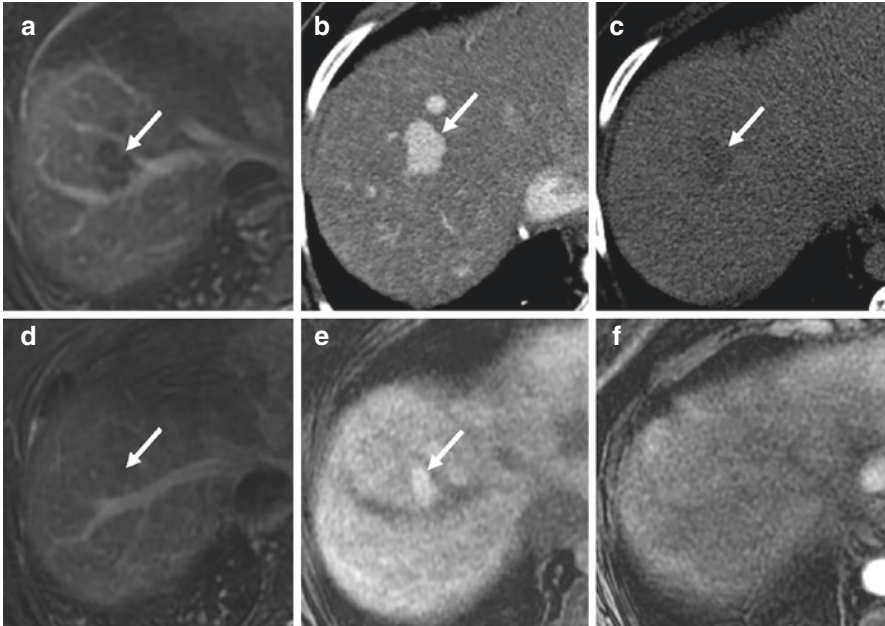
Patient with multiple T2 hypointense masses, one of which is shown (arrow, a). Nodules in this patient showed arterial phase hyperintensity (arrow, b) and delayed phase washout (arrow, c) on CT scan obtained near the time of the initial MRI (MRI was enhanced with gadoxetate disodium making assessment of delayed phase washout unreliable). This patient had numerous follow-up examinations over 25 months of imaging follow-up which demonstrated resolution of both the T2 hypointensity (arrow, d) and delayed phase washout (not shown), possibly reflecting a change in the composition of the background liver parenchyma. The nodule remained present when imaged in the arterial phase and with extracellular contrast agent or in the hepatobiliary phase with intracellular contrast agent (arrow, e). A precontrast image (f) from the study performed in image (e) is provided for reference
